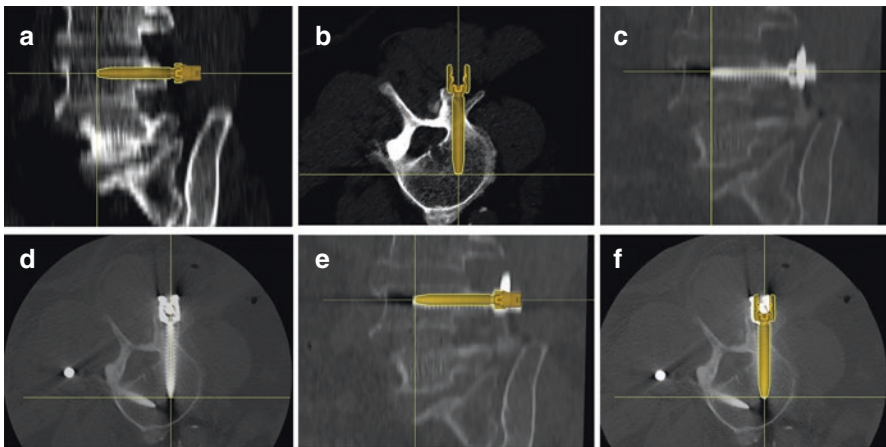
Screw planning and accuracy assessment. Left L4 screw placement is planned using intraoperative software in sagittal (a) and axial (b) planes. The screw trajectory is lateral to medial to facilitate purchase along the medial pedicle wall. The crosshairs indicate the screw tip. Postoperative sagittal (c) and axial (d) CT scans demonstrate screw placement without a medial or lateral breach. Accuracy is assessed using image overlay analysis between preoperative planning and postoperative sagittal (e) and axial (f) CT scans, which show minimal error with a near-overlap of the planned trajectory and the resultant screw. *Used with permission from Barrow Neurological Institute, Phoenix, Arizona*
